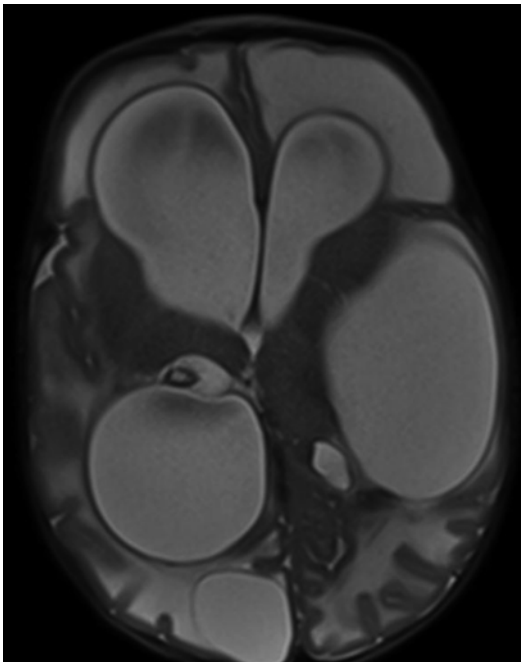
MRI of a 4-month-old patient with a history of multiple intracranial abscesses secondary to *S. aureus* meningitis who developed loculated hydrocephalus requiring multiple shunt placements with endoscopic fenestrations
